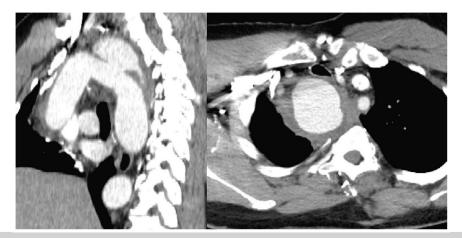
Preoperative computed tomography angiogram of the chest.
